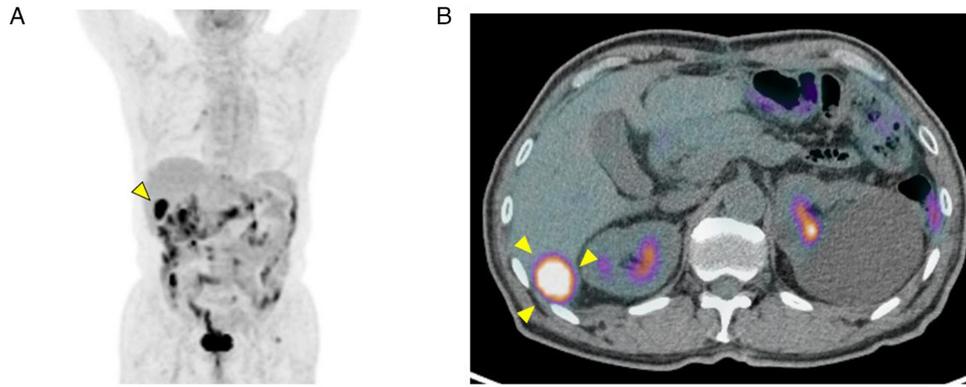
FDG-PET images. PET-CT revealed one significant active deposit in the liver (arrowheads). (A) Numerous intermediately active nodules in the maximal intensity projection were non-specific accumulations of the FDG metabolites in the feces. (B) PET-CT showed a single metastatic nodule (2.5 cm in diameter) with high metabolic activity (standardized uptake value, 10.4) in the posterior segment of the liver. FDG, ¹⁸F-fluorodeoxyglucose; PET, positron emission tomography; CT, computed tomography.
